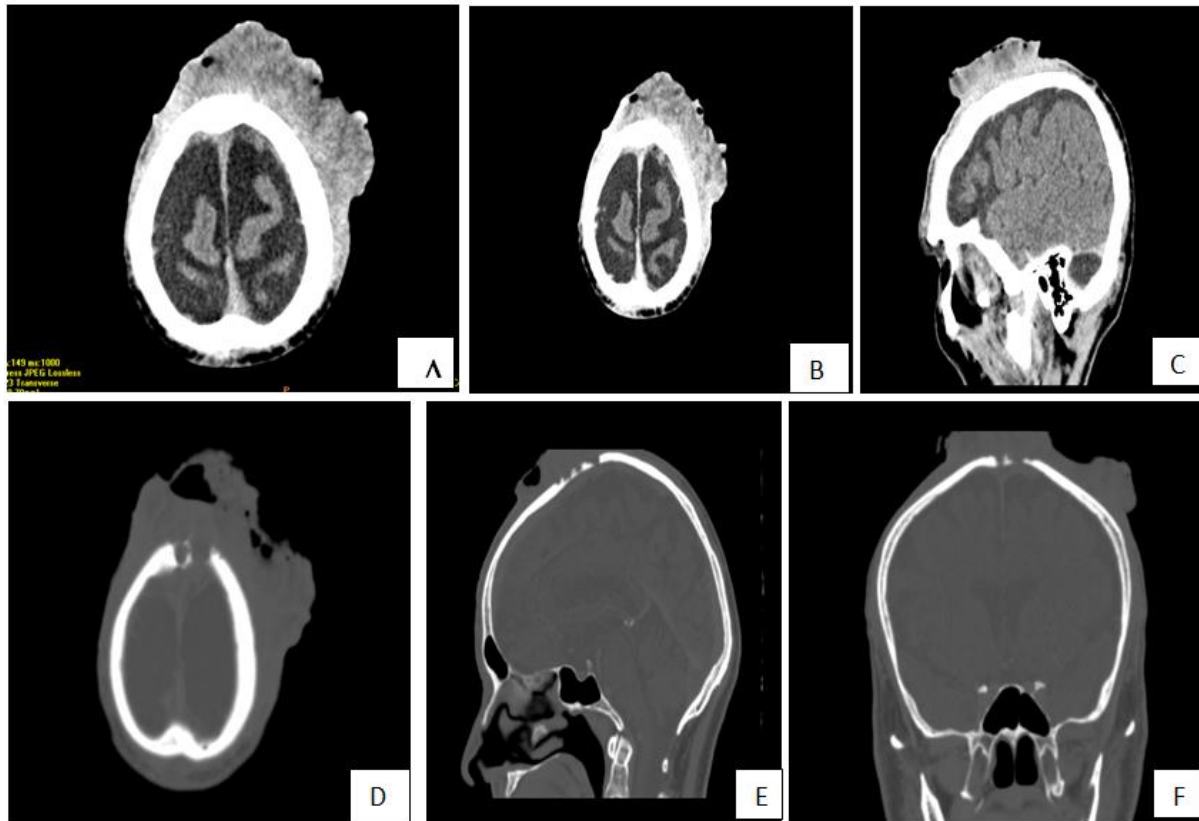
Cerebral CT in parenchymal window (A, B, C). Without contrast medium injection (A); with contrast medium injection (B, C). bone window (D, E, F).
